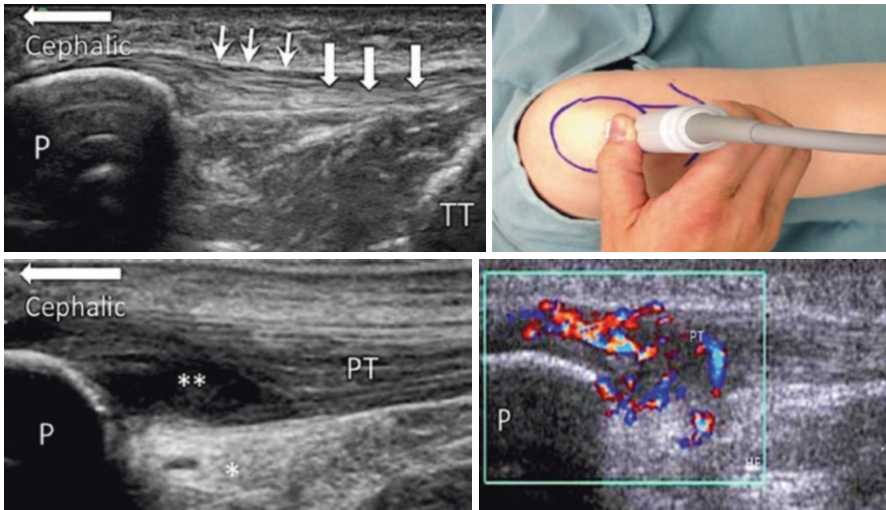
Sonographic images of patella tendon. (Reprinted with permission from Philip Peng Education Series)
